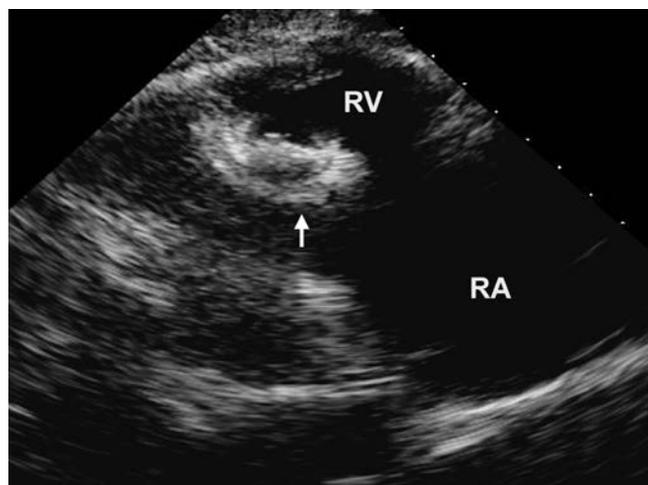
Parasternal long axis view of the right-sided chambers showing an unusual mass (arrow) within the right ventricle.
